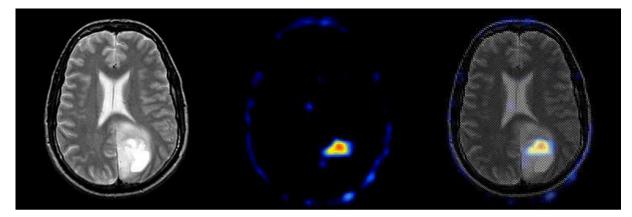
Demonstration of the localization of a brain tumor with MRI and SPECT images (13).
